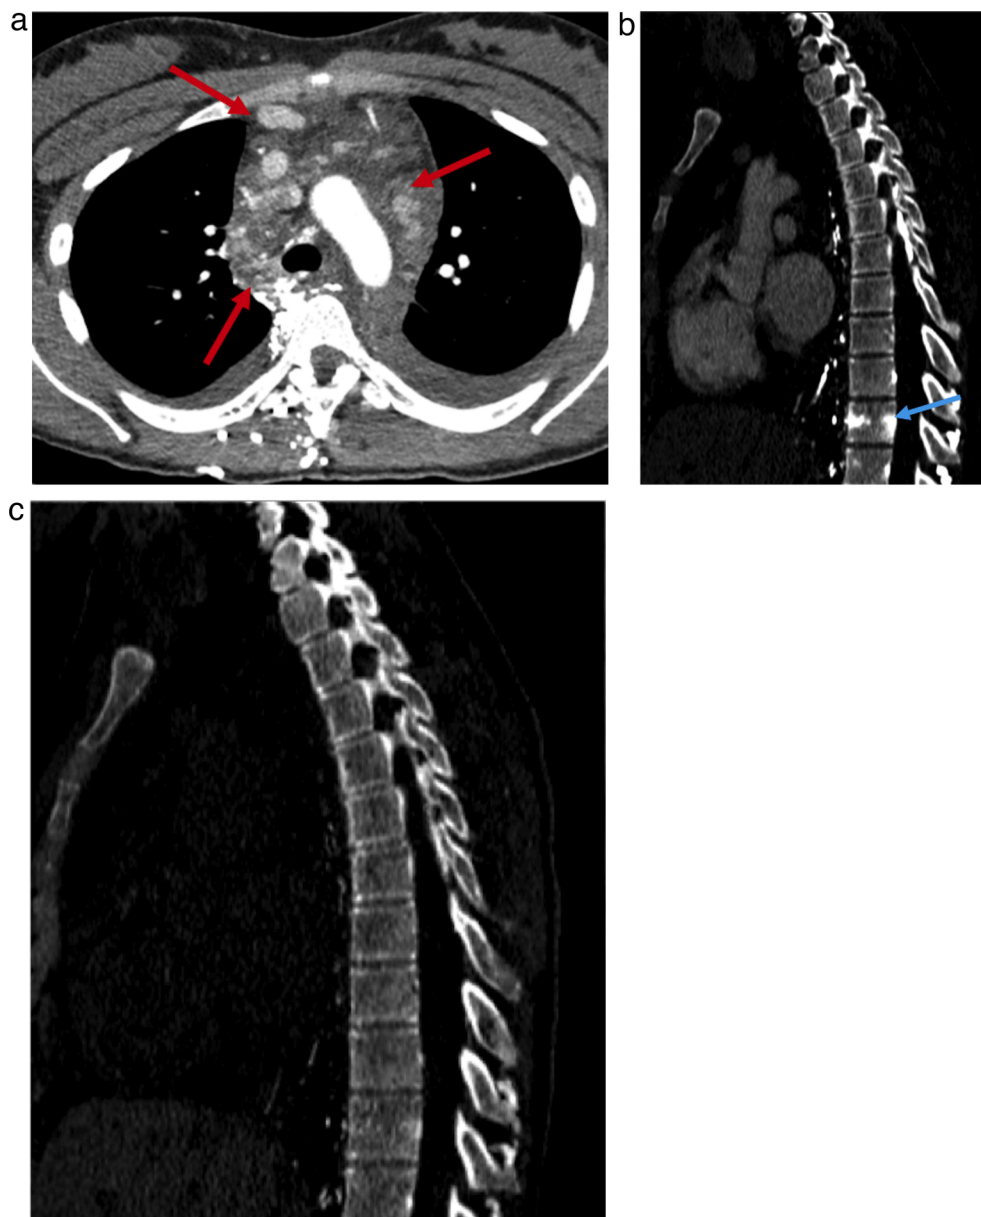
Better lesion characterization with DECT. A 74-year-old male with prior history of mediastinal mass consistent with small cell cancer, status post chemoradiotherapy. Initial conventional CT image (a) shows nonspecific fat stranding and soft tissue density in mediastinum, consistent with combination of tumor and post therapy changes. In addition, there is extensive collateralization in the mediastinum secondary to patients known Superior Vena Cava (SVC) involvement (Arrows in a). There is a new ill-defined hyperdense lesion seen in lower thoracic spine on conventional CT (Aarrow in b), which is indeterminate for metastatic disease. However, the vertebral lesion disappears on VNC image(c) pointing towards intraosseous enhancement secondary to SVC syndrome and not neoplastic lesion.
